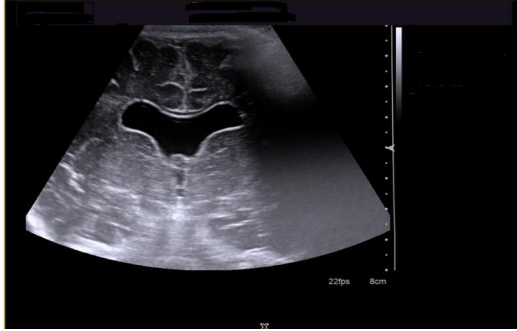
Neurosonogram showing fusion of frontal horns of both lateral ventricles with absent septum pellucidum.
